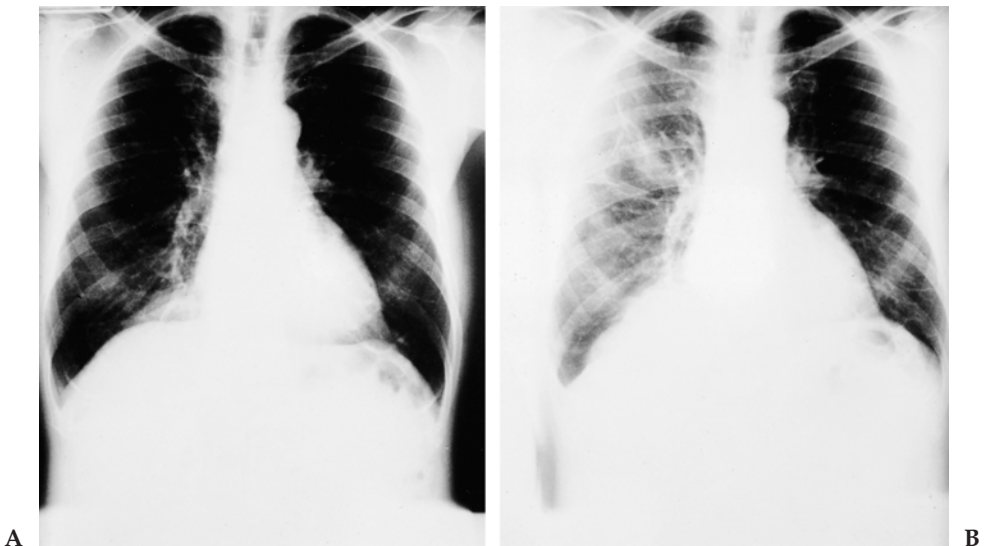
This former asbestos worker was followed by routine periodic chest x-rays. A: A normal x-ray in April 1977. B: Minimal changes on the right side of the diaphragm and blunting of the right costophrenic angle in January 1979. These were the initial signs of pleural mesothelioma.
